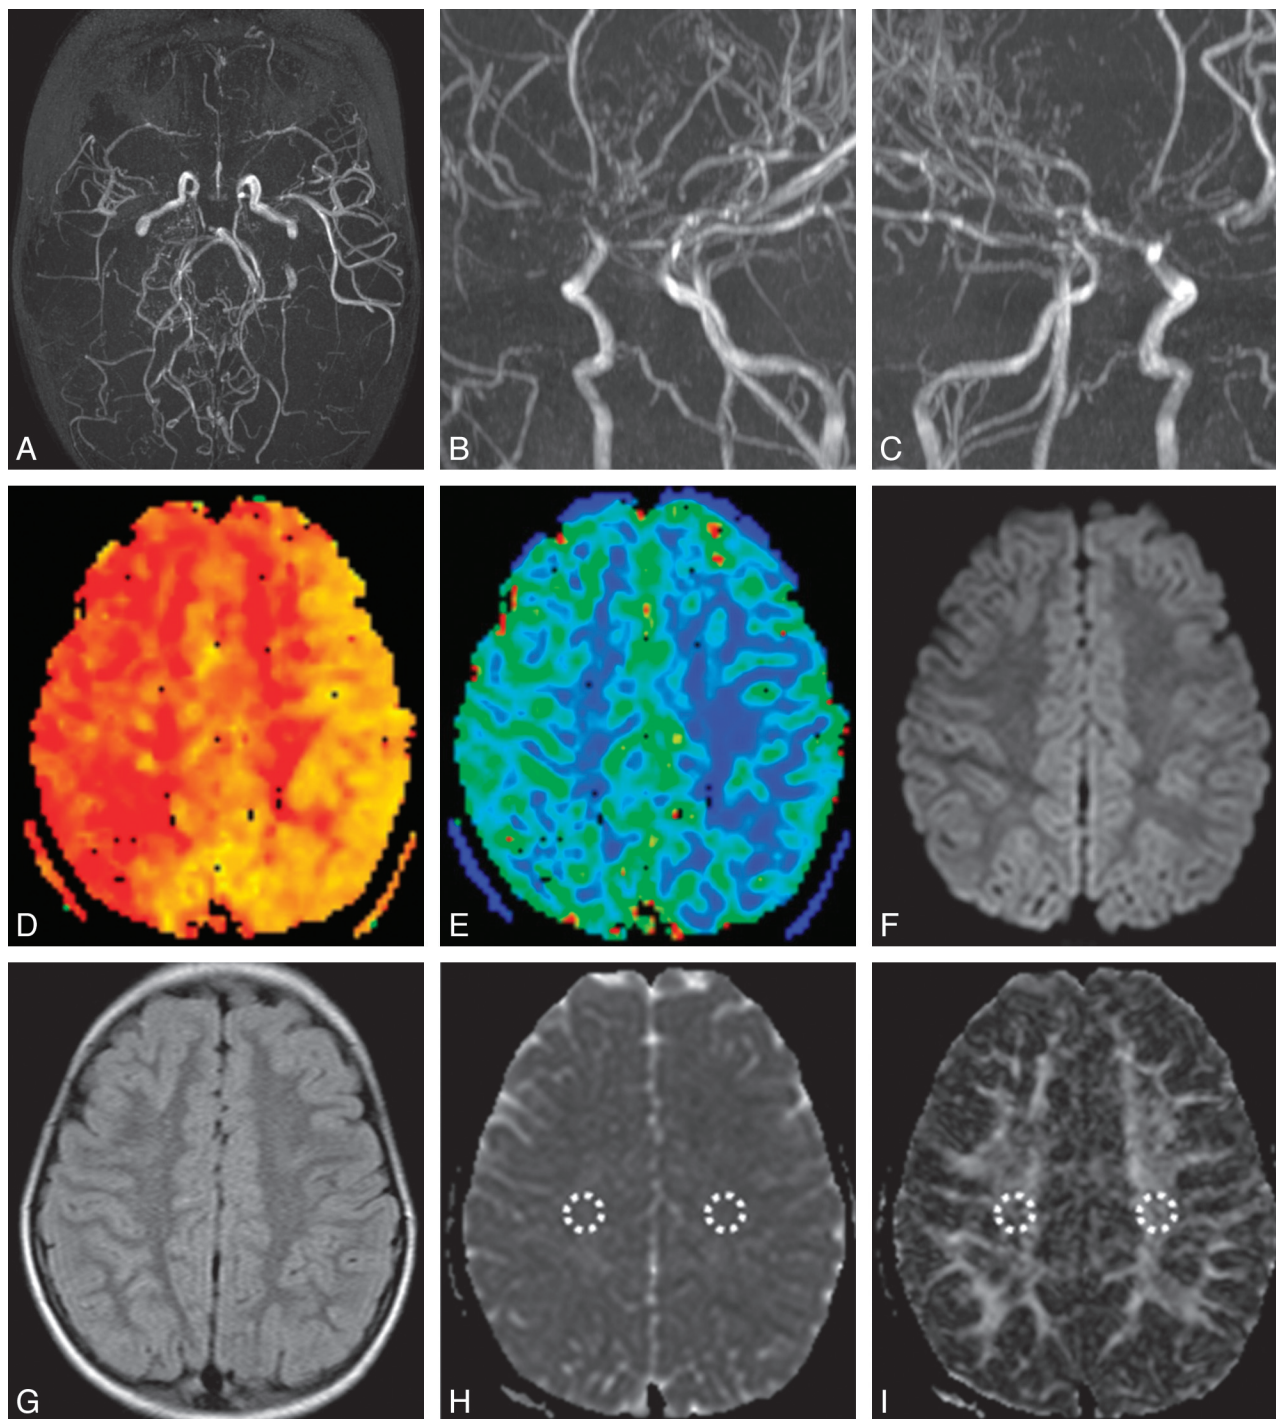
Primary MMD in a 6-year-old girl. A–C, MRA images showed asymmetric MRA cores and stages between both hemispheres (Rt., stage III; Lt., stage II). TTP (D) and CBV (E) maps demonstrated asymmetric hemodynamic status, in which the Rt. hemisphere showed more delayed TTP and increased CBV. Diffusion-weighted image ($b = 1000$; F) and a FLAIR image (G) did not show any abnormalities. H, ADC map, right side ADC_{CS} ($836.3 \text{ mm}^2/\text{s}$) was higher than left side ADC_{CS} ($779.8 \text{ mm}^2/\text{s}$). I, FA map, right side FA_{CS} (0.438×10^{-3}) was lower than left side FA_{CS} (0.487×10^{-3}).
